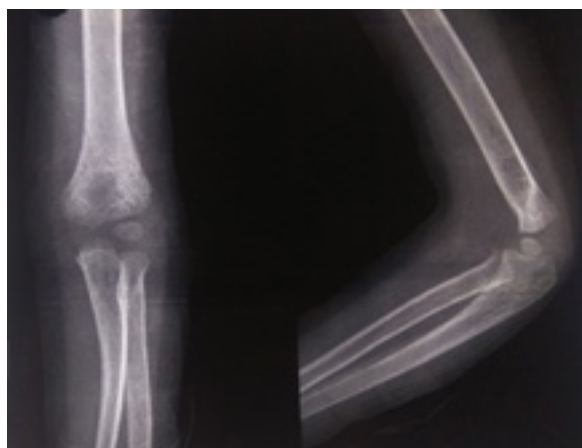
X-ray AP and lateral view elbow after implant removal during follow up.
